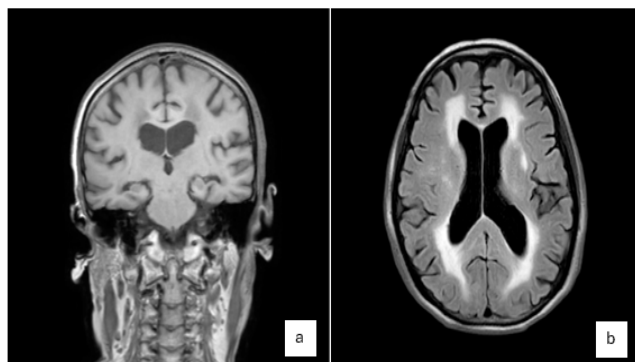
(a) MRI Brain T1 Coronal view -widening of choroid fissure and temporal horn of the lateral ventricle. (b) MRI Brain AXIAL FLAIR- Periventricular hyperintensities
